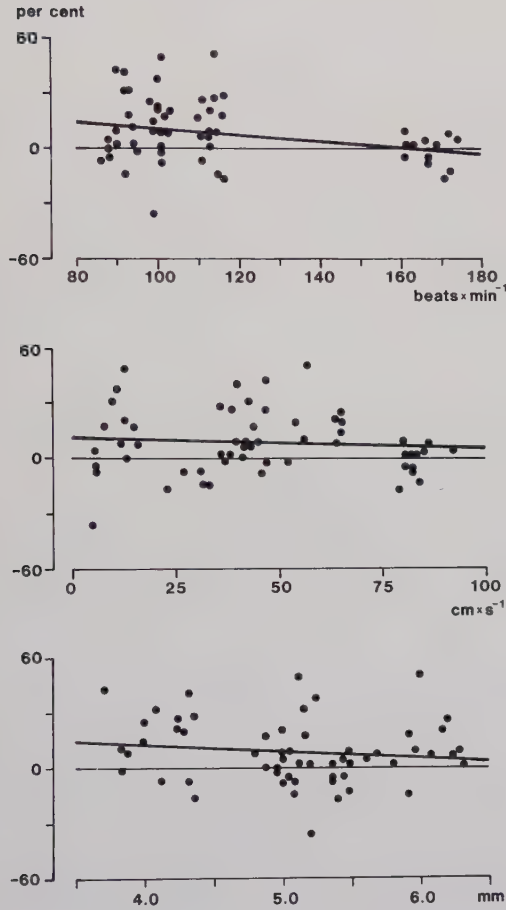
Relation between the percentual difference in the electromagnetically and ultrasonically measured blood flow (ordinate) and heart rate (upper part), mean blood velocity (middle part) and aorta diameter (lower part).
